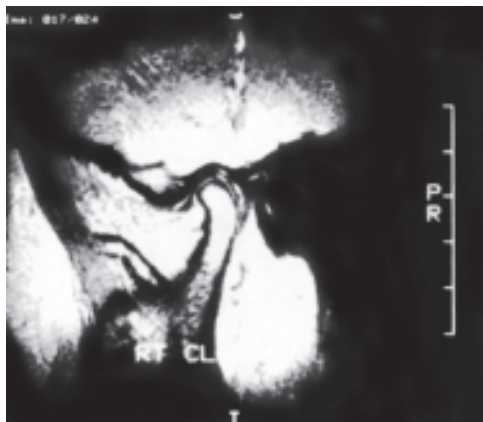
MRI of the TMJ showing articular disk
